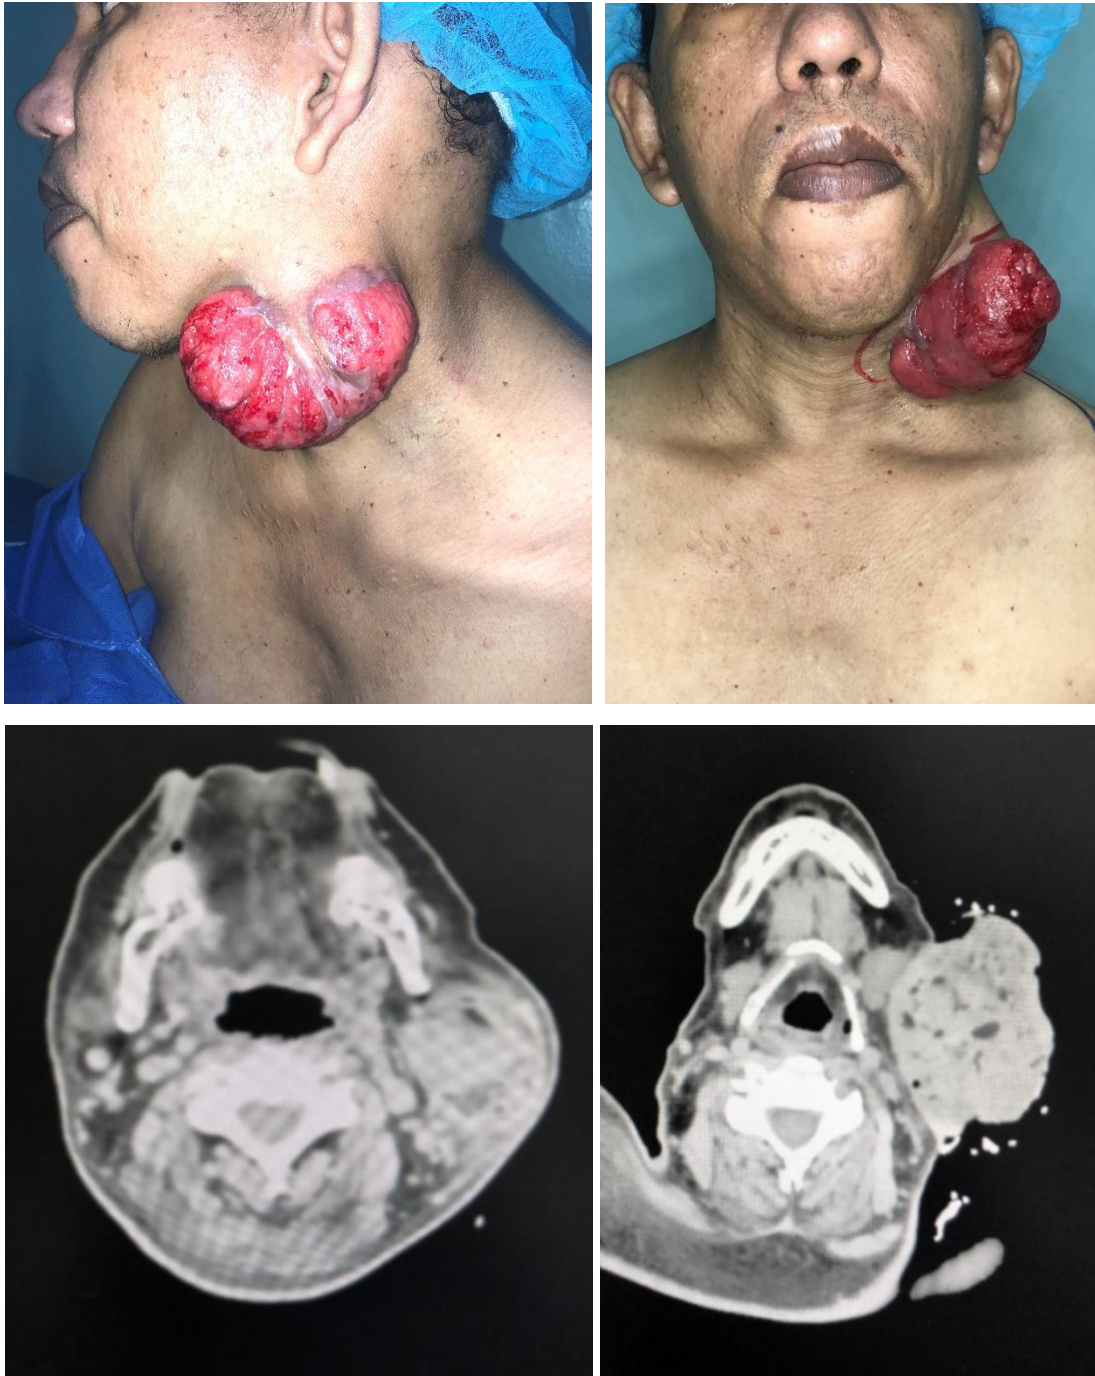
Computed tomography (CT) with contrast showing a heterogeneous, partially cystic mass encompassing superficial and deep lobes of the parotid gland. Note dark areas with consistency of adipose tissue.
